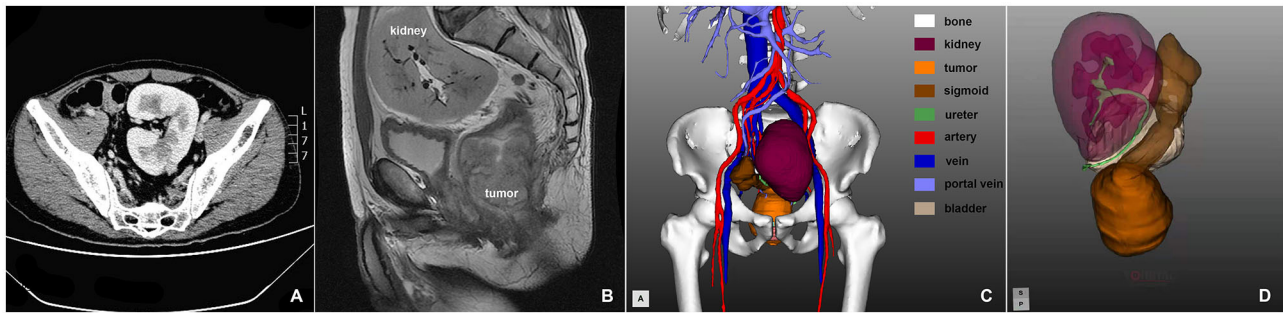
(A) Axial CT scan of the pelvic solitary kidney; (B) sagittal MRI scan of the pelvic solitary kidney and the rectum; (C,D) three-dimensional reconstruction of the pelvic organs.
